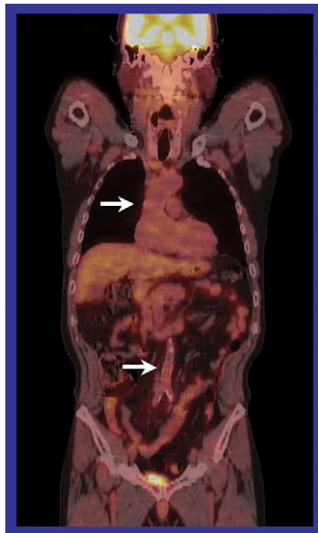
Example of incidental findings in PET/CT screening studies in presumed-to-be-healthy participants. Lesions were identified in the ascending and descending aorta (arrows).
